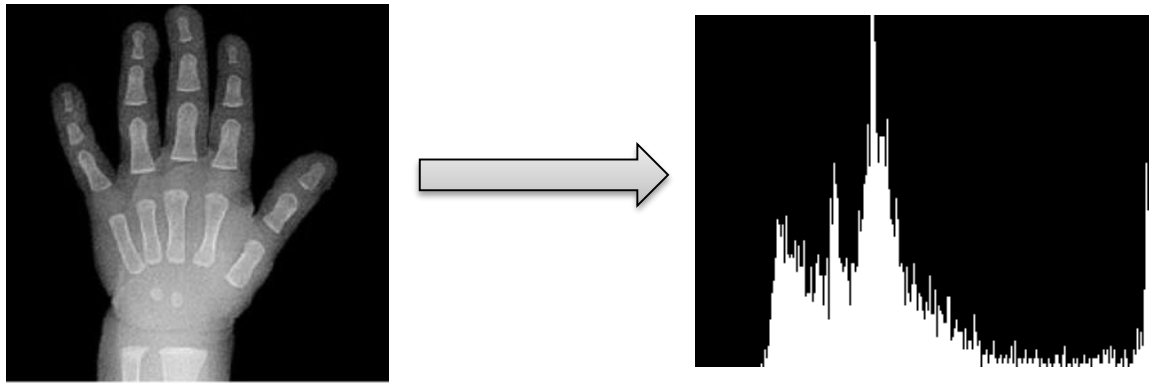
A sample of generated Histogram from an X-ray image
